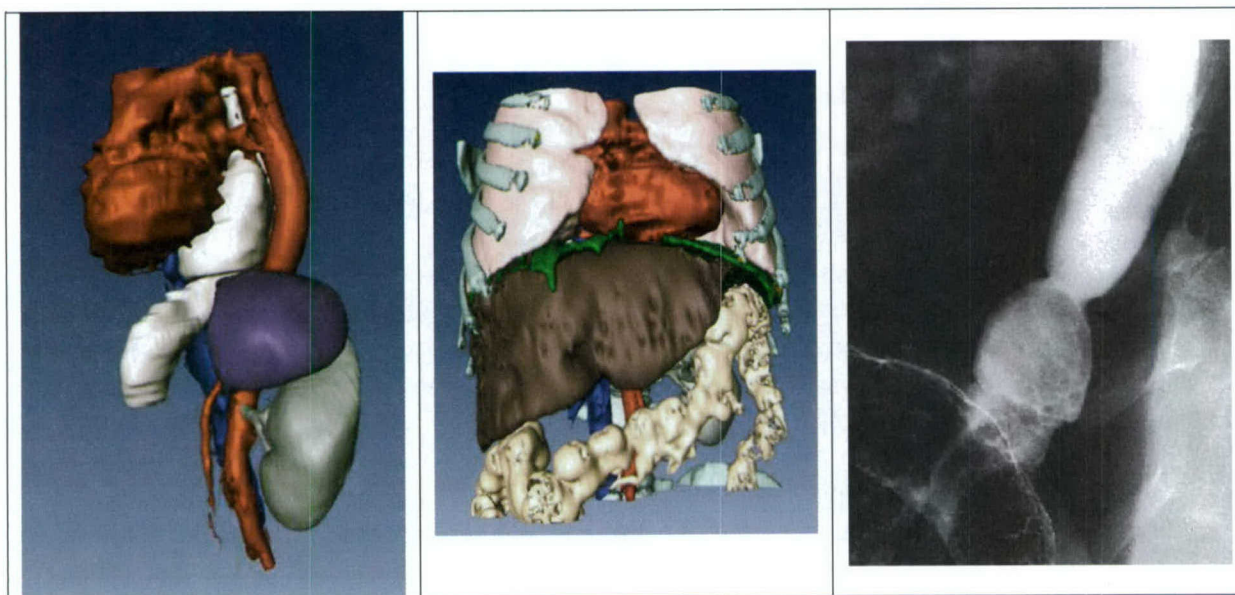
3D visualization for surgical planning. The left and middle images show 3D reconstructions of a patient with a large hiatal hernia (stomach bulging up into chest) for whom a laparoscopic repair is planned. These images are visualized on the computer to allow the surgeon to study and “fly” through the anatomy preoperatively, paying particular attention to relationships between the esophagus and herniated fundus to the heart, lung, aorta, etc. The surgeon can also rehearse port placement, the planned sequence of dissection, and other operative procedures. These reconstructions can greatly enhance patient care over the traditional approach of studying the plain film available from a barium swallow (shown in the right image here).
